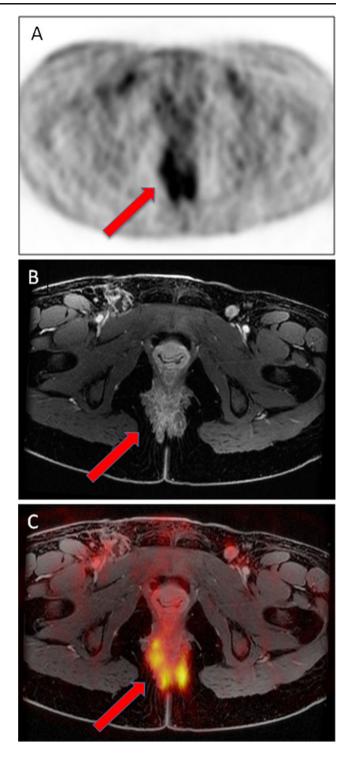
A) 18-FDG PET demonstrating increased metabolic activity in the posterior pelvis. B) MR Axial LAVA FLEX post contrast image demonstrating clear delineation of an enhancing mass in the ischio-rectal fat posterior to the rectum which represents extension in to the parametrium from a rhabdomyosarcoma of the vagina. C) Fused PET-MR demonstrating that the areas of enhancement correspond to areas of increased 18-FDG uptake.
